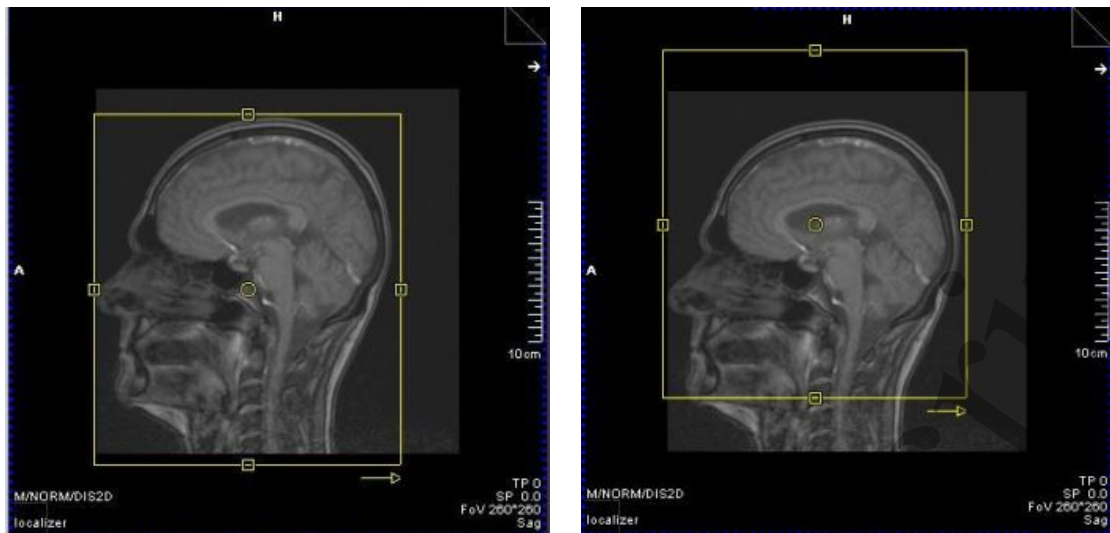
(Left) FOV centred over the whole head, as is routine in diagnostic imaging. This results in the brain being scanned slightly off-isocentre. (Right) The centre of the FOV (hence magnet isocentre) is positioned over the brain, when minimal distortion is required. For example, with MRI planning in SRS cases, the FOV should be centred on the brain and not the whole head, to reduce geometric distortion.
